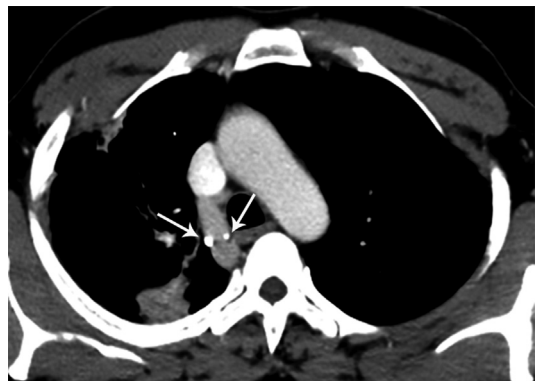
Azygos arch valves in a 68-year-old man with tuberculosis in the right upper lobe. A contrast-enhanced axial CT scan of the chest demonstrates the reflux of intravenous contrast into the azygos vein, lodged within the valves (arrows). Knowledge of the typical appearance and location of the azygos arch valves is important in avoiding misinterpretation as calcified lymph nodes, calcified thrombus or a foreign body.
